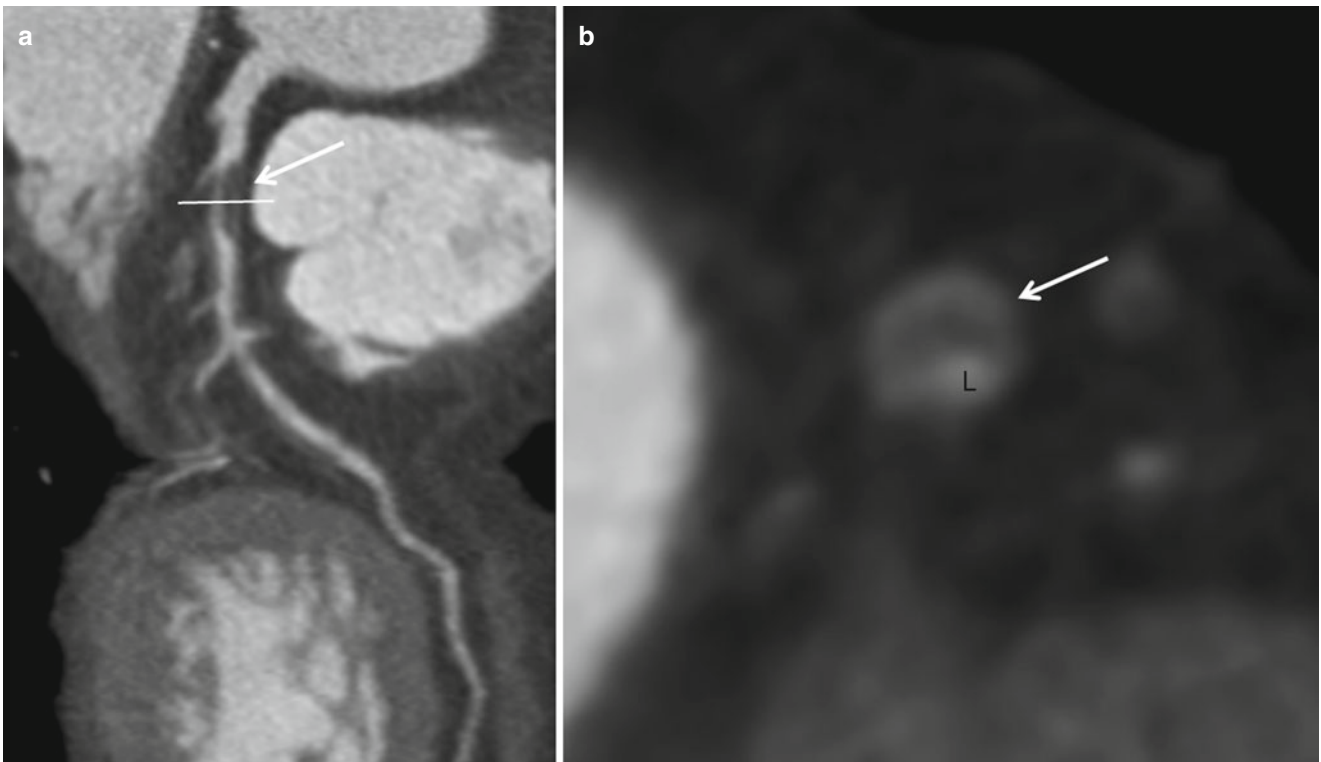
Napkin-ring sign in a 63-year-old man with chest pain. (a) Curved multiplanar reformatted (MPR) image demonstrates non-calcified plaque with low attenuation (*arrow*) in the proximal segment of the left anterior descending coronary artery (LAD). (b) Cross-sectional image of CCTA on the level of the *white line* on image a. The CT image
